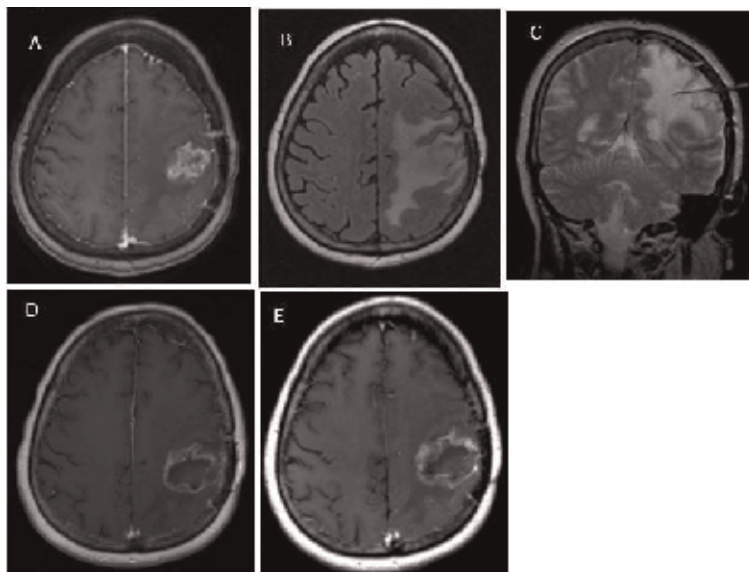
A 58-year-old female with left frontoparietal ring-enhancing lesion T1-weighted axial MRI with contrast suspicious for tumor recurrence (A) with surrounding peripheral edema on T2-weighted FLAIR sequence (B). Intraoperative sagittal T2-weighted MRI showing correct positioning of the laser probe to the lesion (C). Postoperative day 1 of axial T1-weighted MRI (D) demonstrates subtotal (~70%) thermal ablation of the lesion. Follow-up T1-weighted MRI with contrast approximately 9-week post-LITT demonstrates tumor progression (E).
